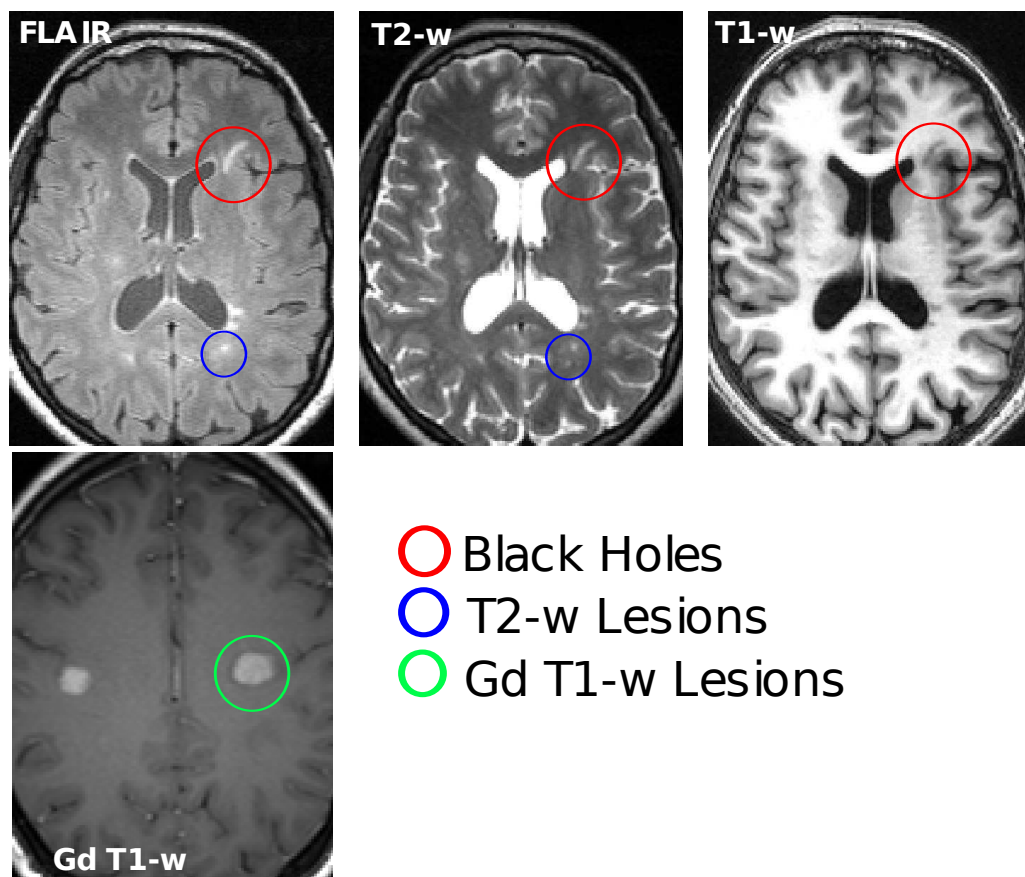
Examples of MS lesions on MRI: T1-w, T2-w, FLAIR and gadolinium enhanced T1-w (Gd T1-w).
